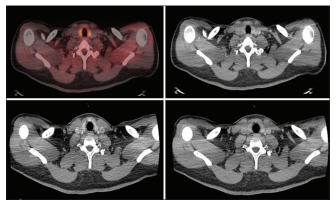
Axial ¹⁸F-FCH PET/CT images of the same patient as mentioned above demonstrating nonlocalization of culprit lesion (upper row) and corresponding axial 4D-CT neck arterial and venous phase images also demonstrate nonlocalization (lower row). PET/CT: Positron emission tomography/computed tomography, 4D-CT: Four-dimensional-computed tomography
